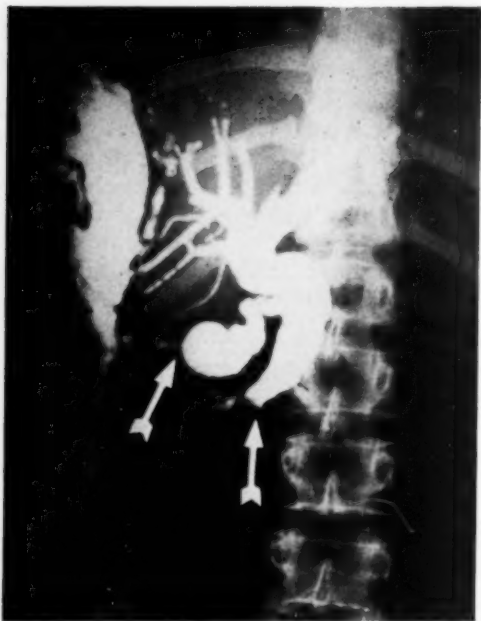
Roentgenogram showing site of previous rupture of gallbladder, obstruction at ampulla of Vater, and large sinus tract.
